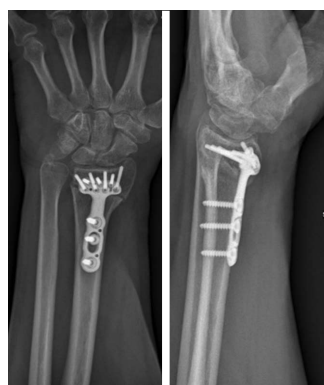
X-rays performed 3 mo post-operatively showing the healing process in progress.
